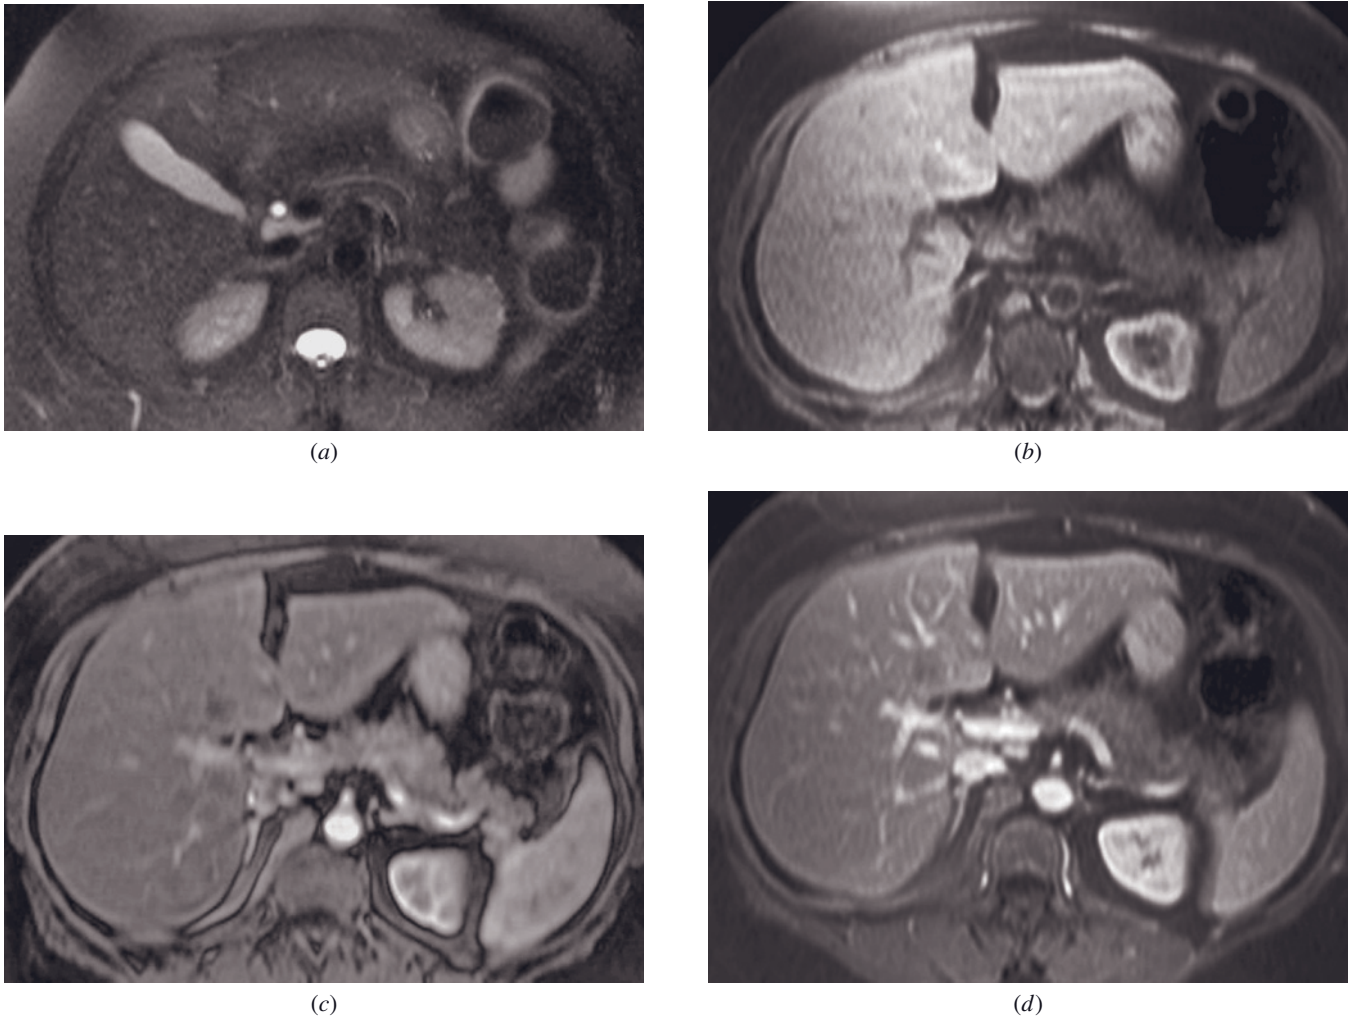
Early chronic pancreatitis. Fat-suppressed T2-weighted SS-ETSE (a), fat-suppressed T1-weighted gradient-echo (b), and immediate (c) and interstitial-phase (d) postgadolinium fat-suppressed T1-weighted gradient-echo images in a patient with early chronic pancreatitis demonstrate mildly diminished signal intensity on fat-suppressed and immediate postgadolinium T1-weighted images. Low signal intensity on T1-weighted fat-suppressed image (b) reflects loss of aqueous protein in the acini of the pancreas. Diminished enhancement on capillary-phase image (c) reflects disruption of the normal capillary bed due to chronic inflammation and fibrous tissue.
